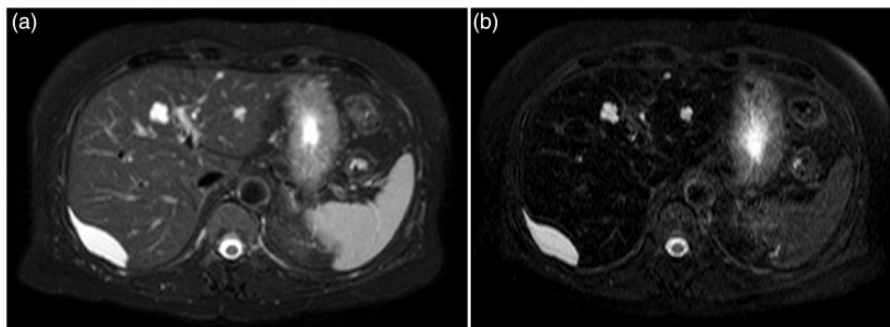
MRI of the liver with and without SPIO. (a) Axial T2W sequence with fat suppression showing two hyperintense, lobulated cyst-like lesions in segments II and IV, and one 6 cm sub-capsular lens-shaped lesion in segment VII. (b) Following SPIO four additional sub-centimeter lesions were detected.
